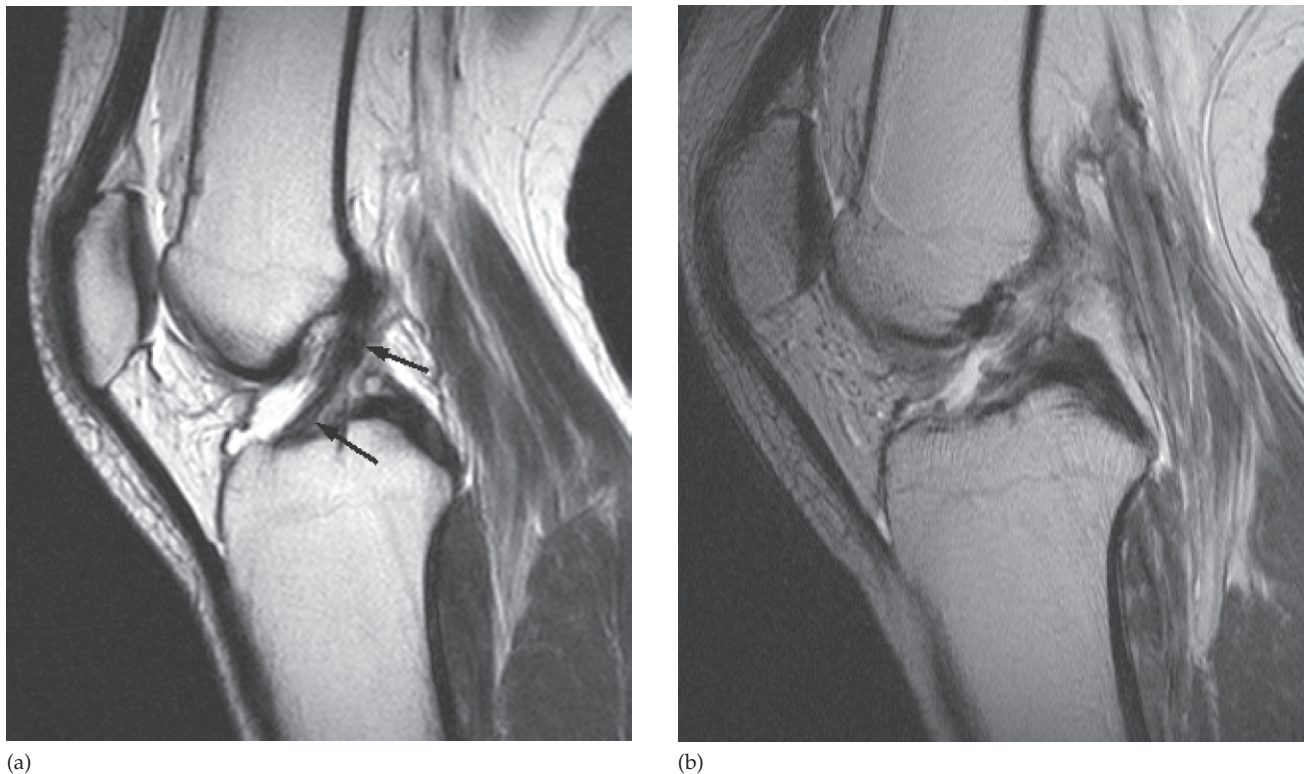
(a) Normal anterior cruciate ligament is shown as a low signal band in the intercondylar notch (arrows) on this MRI scan. (b) With a tear the ligament is disrupted.
